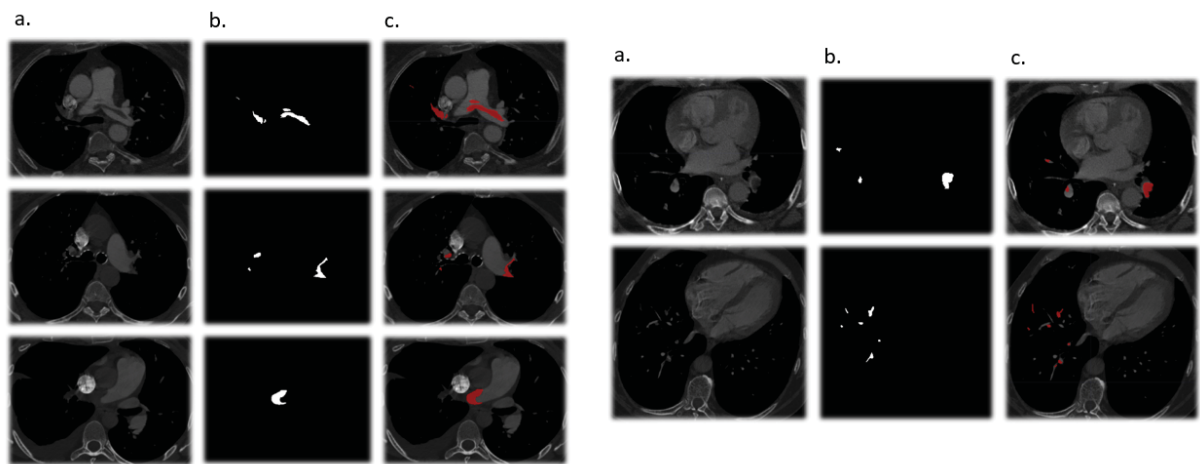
Pixel level annotation. In column (a) CTA image of PE in different anatomical locations. In column (b) pixel level annotation showing in white all pixels of the PE of the corresponding CTA image in column (a). In column (c) superposition of the corresponding image of columns (a) and (b), with the thrombus in red.
